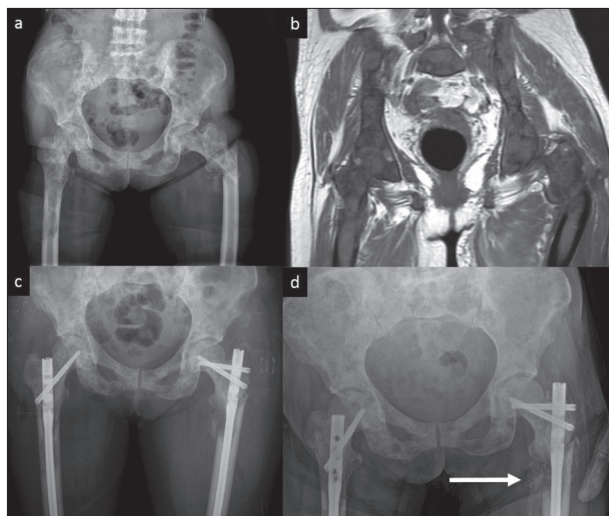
Case 17: a) Anteroposterior view of the bilateral femoral metastatic lesions with left impending and right complete fracture (62-year-old female, breast carcinoma); b) Magnetic resonance imaging view of the bilateral femoral metastatic lesions; c) Postoperative view of the bilateral femur; d) three-month follow-up; Callus formation at fracture site, indicating complete response to adjuvant radiotherapy (white arrow)
